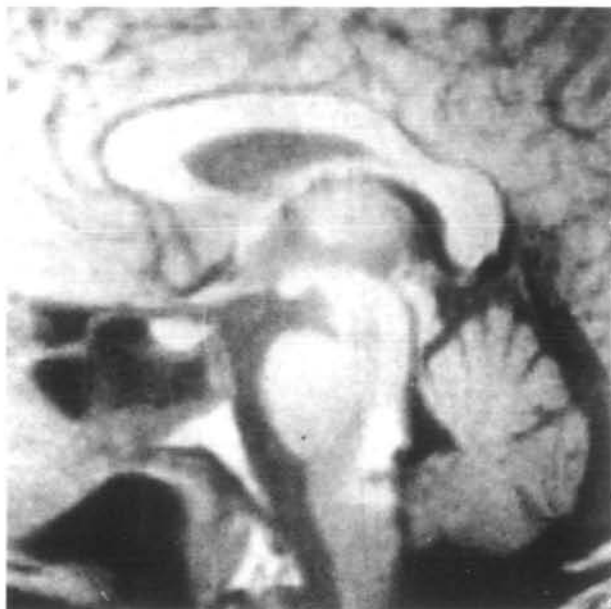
Sagittal T<sub>1</sub>-weighted (repetition time, 520 milliseconds; echo time, 21 milliseconds) magnetic resonance imaging scan showing a dorsal medullary hemorrhage with pontine extension.
